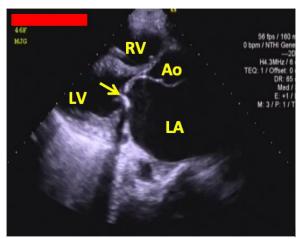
Pre-operative 2D-echocardiography showing severe mitral stenosis (yellow arrow) with area of 0.7 cm² and dilated LA with no thrombus formation. LA = Left Atrium, LV = Left Ventricle, RV = Right Ventricle, Ao = Aorta
